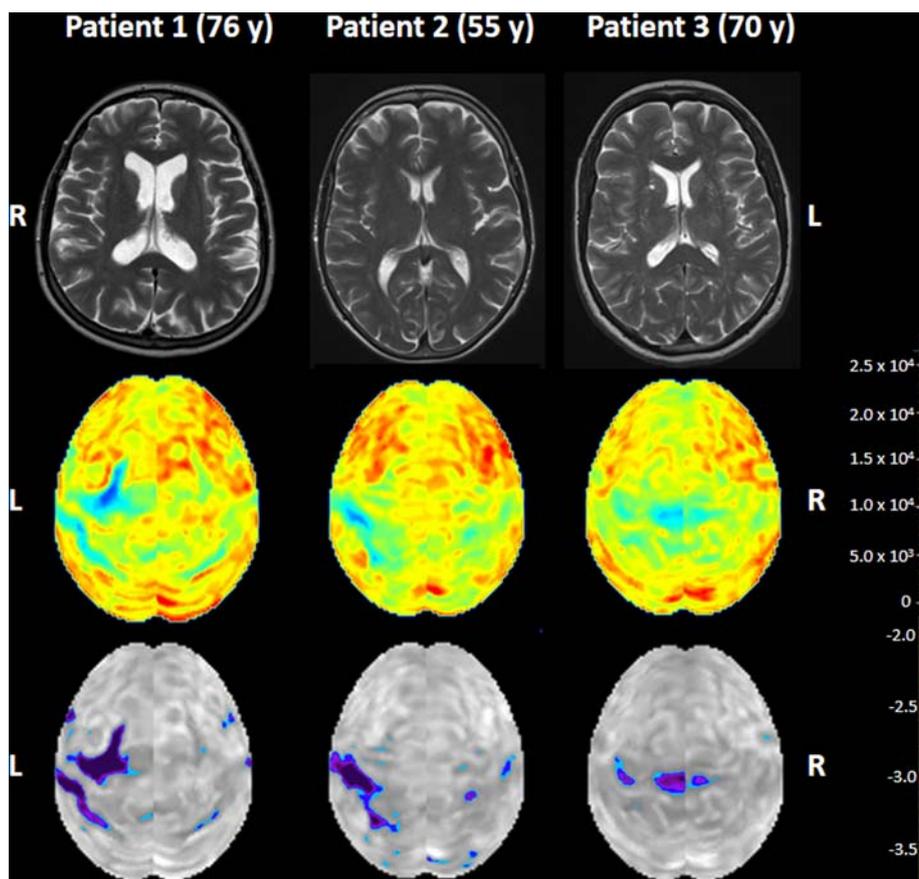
T2-weighted MRI (upper row) and stereotactic surface projections of the brain 18-fluorodeoxyglucose-positron-emission tomography (FDG-PET; middle row, cranial view) with corresponding Z-score images (comparing patient to healthy volunteers; lower row). No lesions on MRI that could explain the hypometabolism on FDG-PET were noted.
